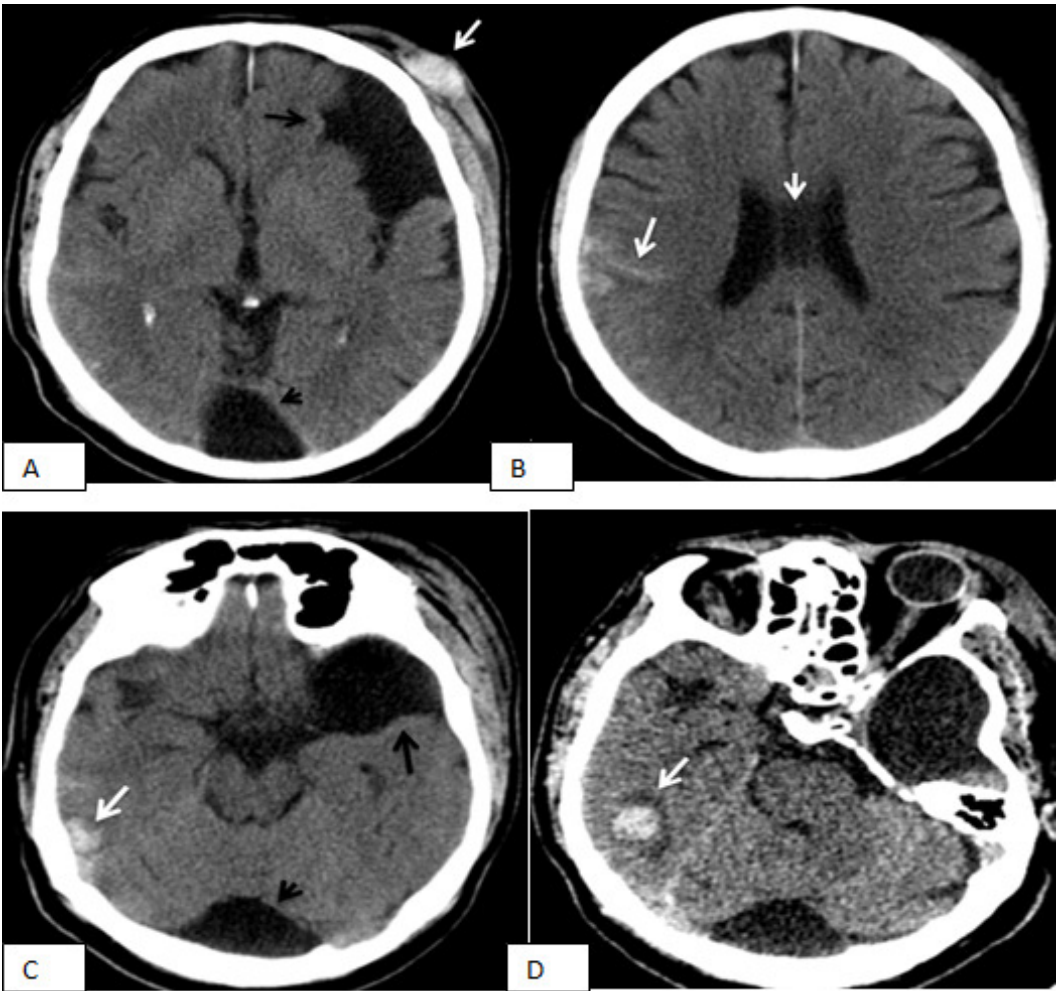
Initial head CT images show the left frontotemporal subgaleal hematoma (A, white arrow), hemorrhagic contusions and focal subarachnoid hemorrhages at the right frontal lobe (B, white arrow) and the right temporal lobe (C, white arrow). Note the presence of a large middle cranial fossa AC compressing the temporal lobe on the left side (A, C, black arrow), mega cisterna magna (A, B, short black arrow) and cavum septum pellucidum (c, short white arrow). Follow-up CT scan after 3 days from the trauma shows the hemorrhagic contusion which is more prominent due to the surrounding edema (D, white arrow)
